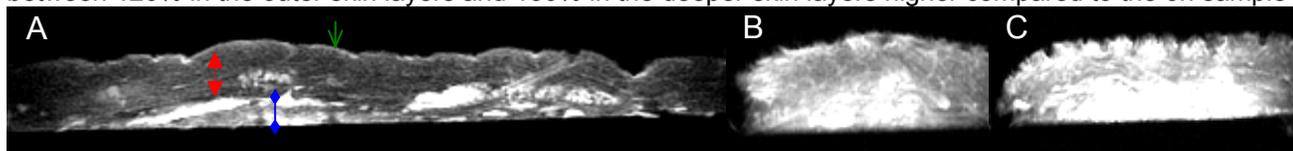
T1-weighted TSE-Images: untreated skin (A), green arrow marks the epidermis, dermis is red and part of hypodermis marked is blue; Gadobutrol treated skin (6 hours = B, 24 hours = C) show high contrast media uptake
